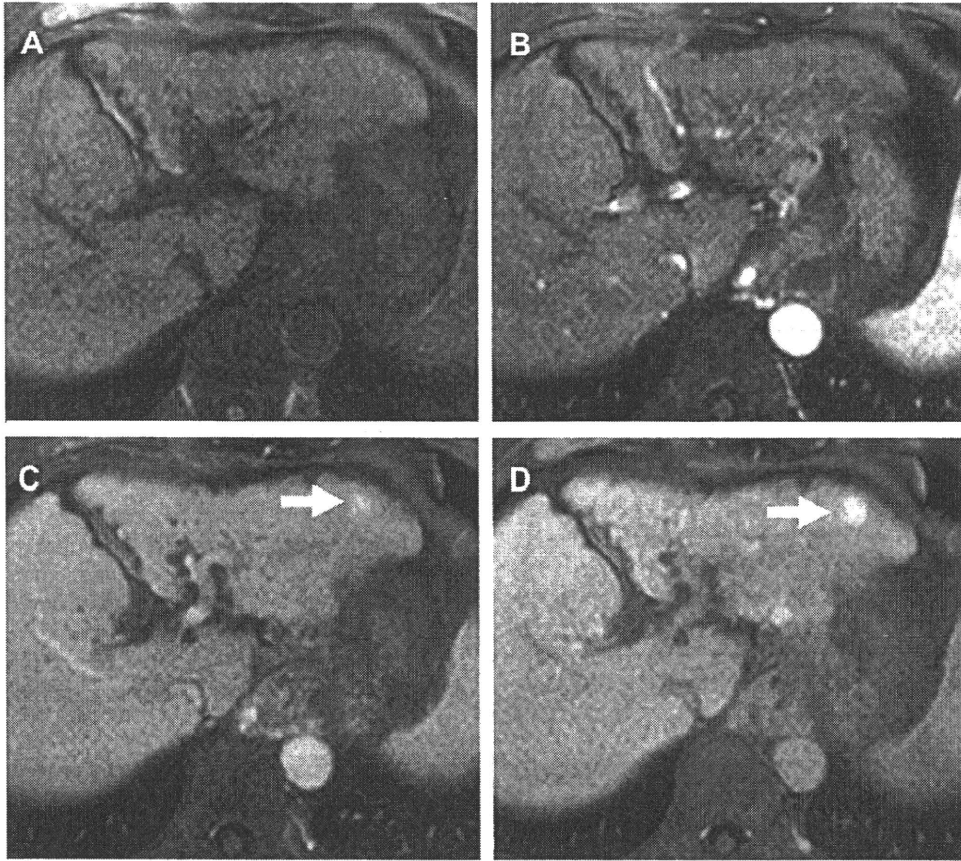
Dynamic enhancement patterns of a high-grade dysplastic nodule in axial T1-weighted fat-saturated 3D GRE images (TR/TE = 3.6/1.7 ms, flip angle = 15°), presenting before (A) and in the arterial phase (30 s) (B), portal phase (90 s), and (C) equilibrium phase (4 min), and (D) after intravenous injection of Gd-EOB-DTPA. Portal and equilibrium phases (arrow) show increased enhancement of high-grade dysplastic nodule.
